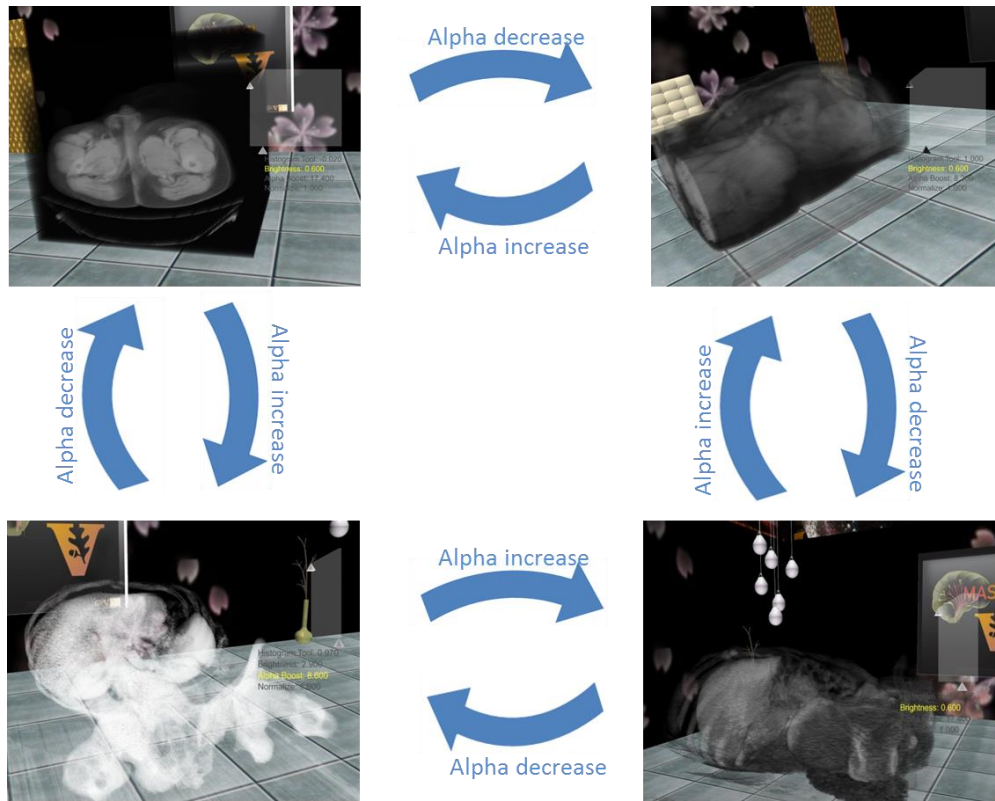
Volume rendering for abdominal wall CT scan.
